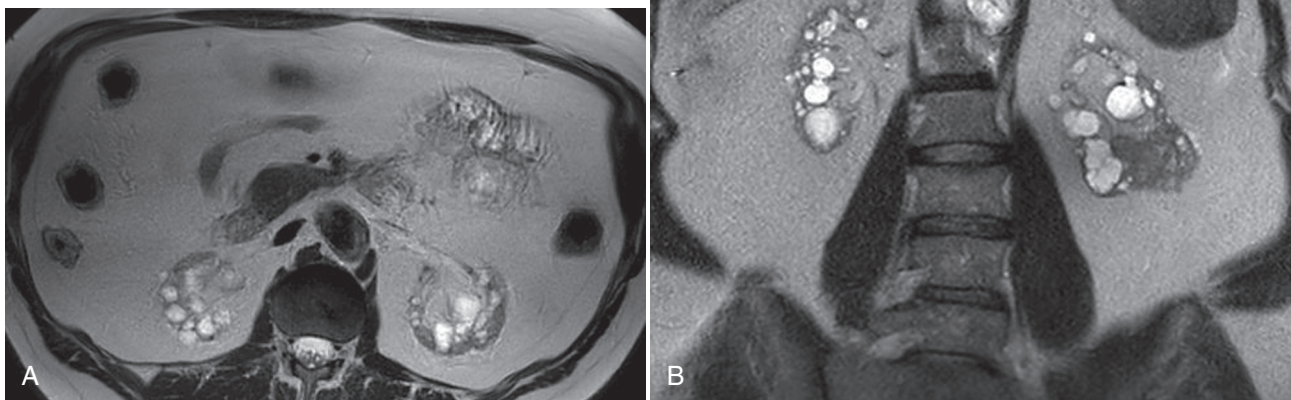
Magnetic Resonance Imaging: Half-Fourier-Acquired Single-shot Turbo spin Echo (HASTE): axial plane (A) and coronal plane (B). Bilateral pyelonephritis. Axial and coronal contrast-enhanced computed tomography in a female patient with acute pyelonephritis and reduced renal function. The kidneys are bilaterally enlarged with wedge-shaped or round hypodense areas and decreased density of the renal parenchyma.
